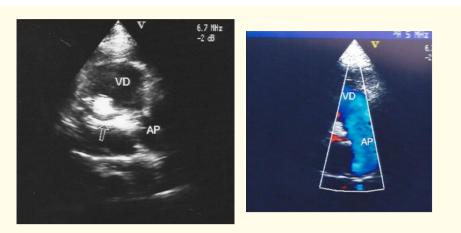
Modified parasternal short-axis view identified left main coronary artery from the main pulmonary artery and the shunt from it to the pulmonary artery indicated as a red flow on colour Doppler.
